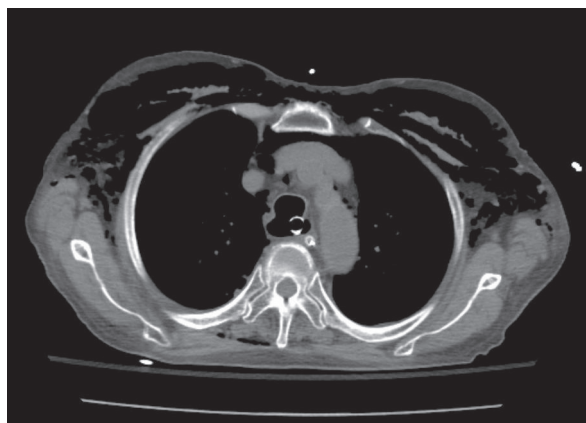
Chest computed tomography reveals a defect in the posterior trachea.
